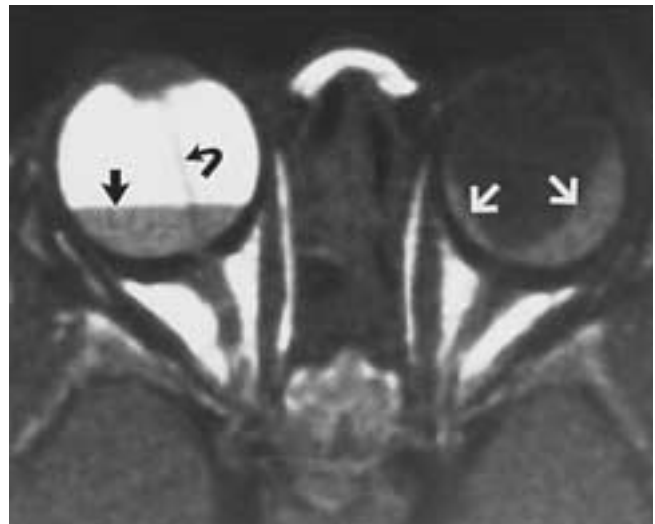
PHPV. This 5-month-old girl was diagnosed as having Warburg's syndrome (congenital oculocerebral disorder). Axial T1-weighted MR image shows hyperintense subretinal fluid in the left eye with a detached retina (arrows). Note the fluid-fluid level in the right vitreous (solid arrow). This is thought to be caused by chronic (hyperintense) and acute (hypointense) hemorrhage in the subhyaloid or subretinal space. Note the tubular image (curved arrow), which suggests a congenital nonattached retina or Cloquet's canal.
